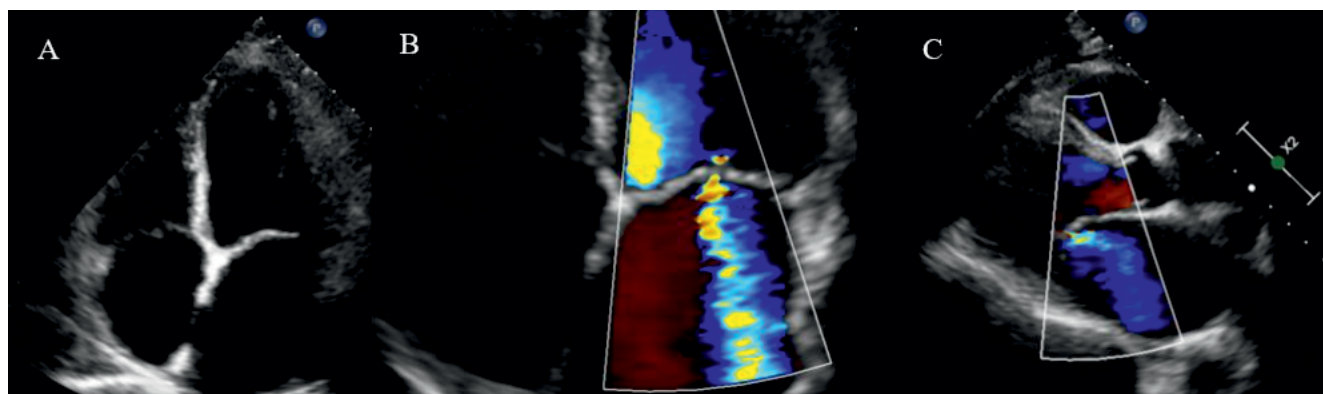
Transthoracic echocardiography: A. Four-chamber apical view-complete resolution of the left ventricular apical thrombus. B. Four-chamber apical view-Mitral regurgitation. C. Parasternal long-axis view-Moderate mitral regurgitation.
